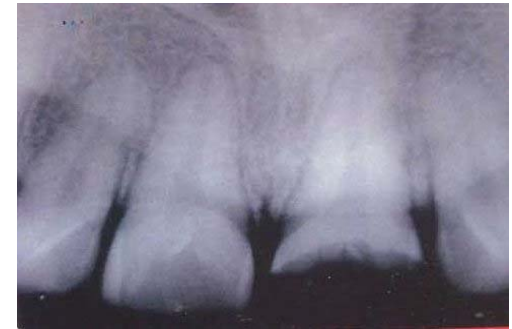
Pre-Operative Iopa X-Ray
